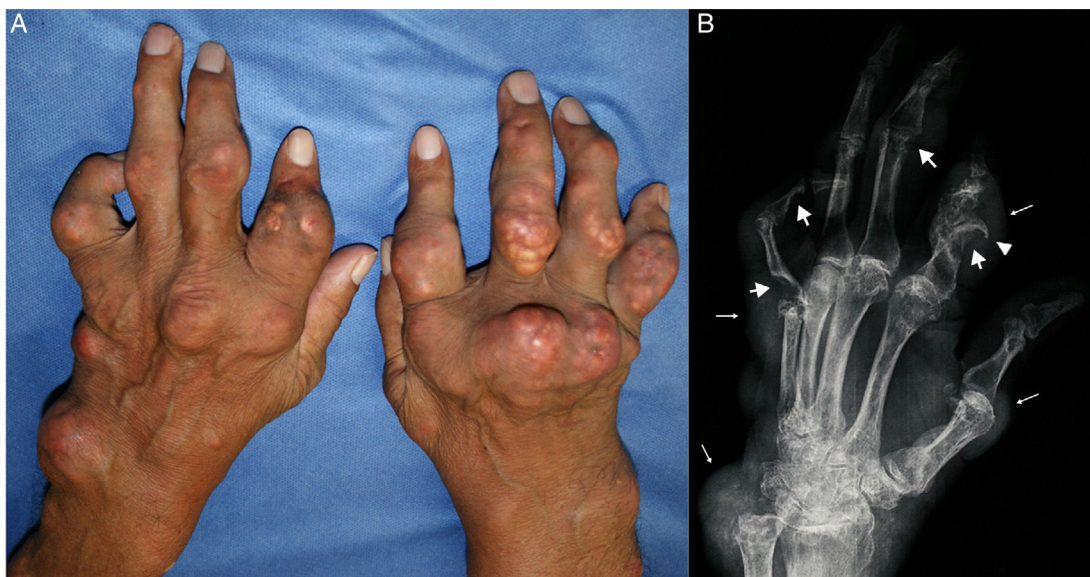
(A) Tophaceous gout with multiple tophi on both hands. (B) The left hand X-ray shows punched-out erosions (thick arrows) with overhanging edges (arrowhead) and soft tissue nodules (thin arrows), findings suggestive of gout.
